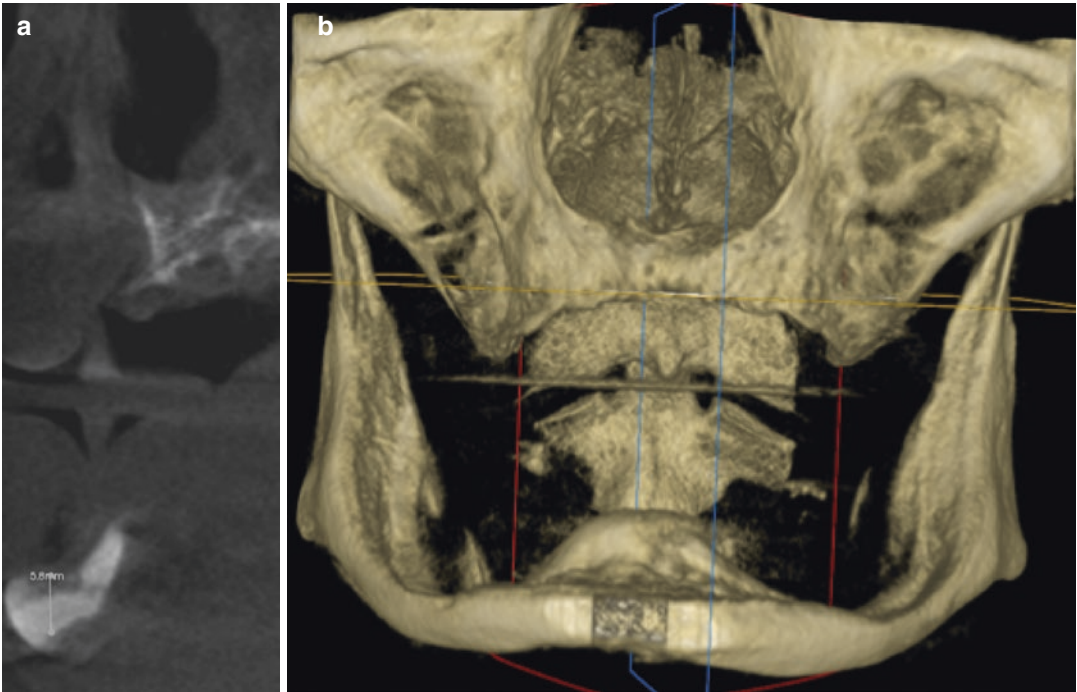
(a) CBCT sagittal view of implant case #2. (b) 3D reformat of implant case #2. (Image Courtesy of Dr. Robert Reti)
